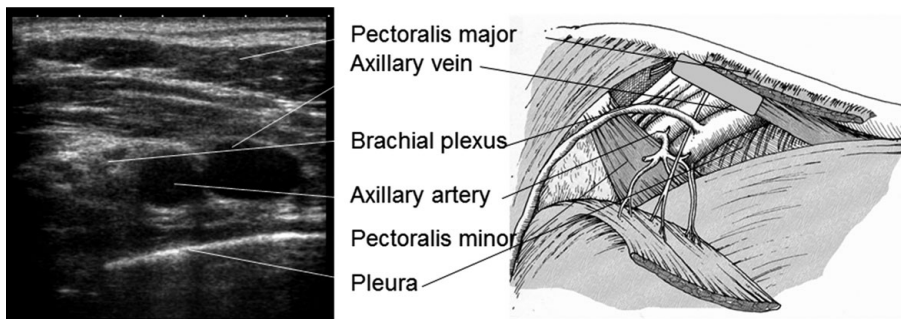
Intraclavicular anatomy. Reproduced with permission from Arthurs G, Nicholls B (eds.) 2016. *Ultrasound in Anesthesia, Critical Care, and Pain Management*. Cambridge, UK: Cambridge University Press
